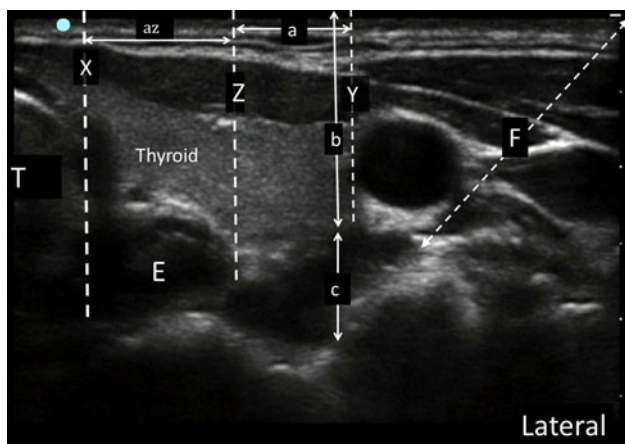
Ultrasound image of the neck at the C6 level on the left side with reference lines and measurements. Line X = line drawn anteroposteriorly on the lateral border of the airway; Line Y = line drawn anteroposteriorly on the medial border of the carotid artery. Line Z = line drawn anteroposteriorly on the lateral border of the esophagus. Line F = line drawn to bisect the shortest distance between the medial border of the carotid artery and the anterior tubercle, from the skin to the prevertebral fascia; az = anterior zone; a = distance between lines Y and Z; b = distance from skin to prevertebral fascia; c = thickness of longus colli muscle; AT = anterior tubercle of C6; C = carotid artery; E = esophagus; LC = longus colli muscle; T = airway
